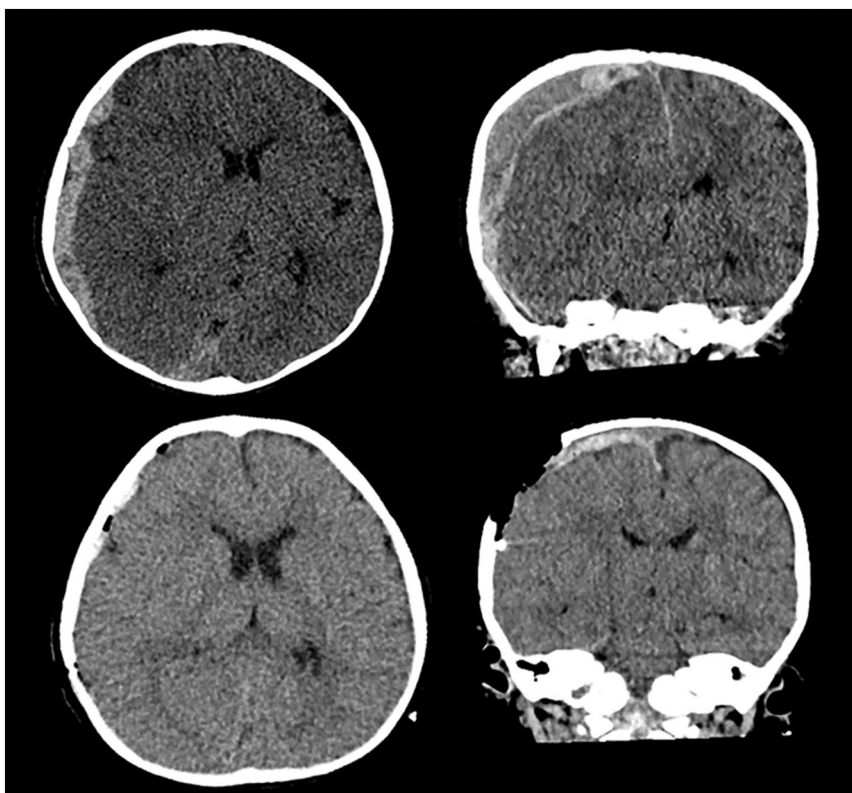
Patient head computed tomography (CT). Top row: axial non-contrast enhanced CT including coronal Multiplanar Reconstruction (MPR) reveals a large undulated subdural, mixed hyper- and hypodense hematoma overlying the right cerebral hemisphere with resultant significant mass effect. The right cerebral hemisphere including right lateral ventricle is herniating across the midline with bowing of the falx to the left. Bottom row: subsequent follow up CT shows a marked improvement of the midline shift after evacuation of the subdural hematoma. Air inclusions are seen along the craniectomy site, part of the fronto-parietal bony skull has been removed.
